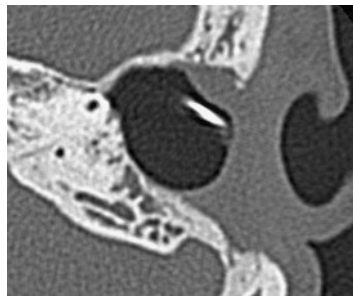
CT scan image after the first-stage operation. The mastoid cavity is fully pneumatized.
